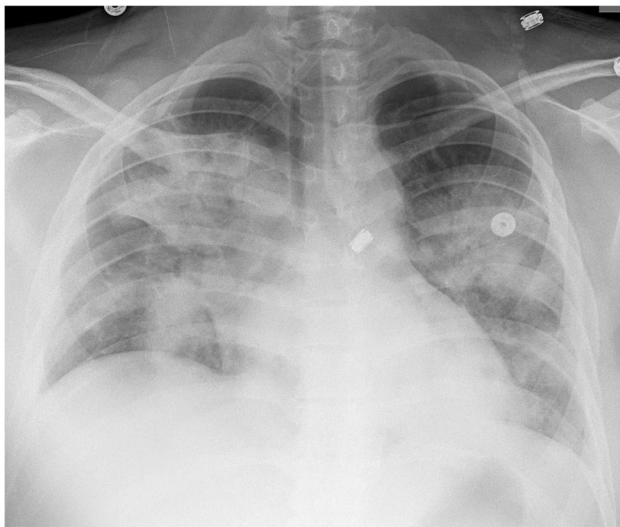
Radiography of consolidation in acute coronavirus disease 2019 (COVID-19) pneumonia in a 20-year-old man. He presented with fever, cough and dyspnea. Anteroposterior chest radiograph demonstrates multiple confluent regions of consolidation throughout both lungs
